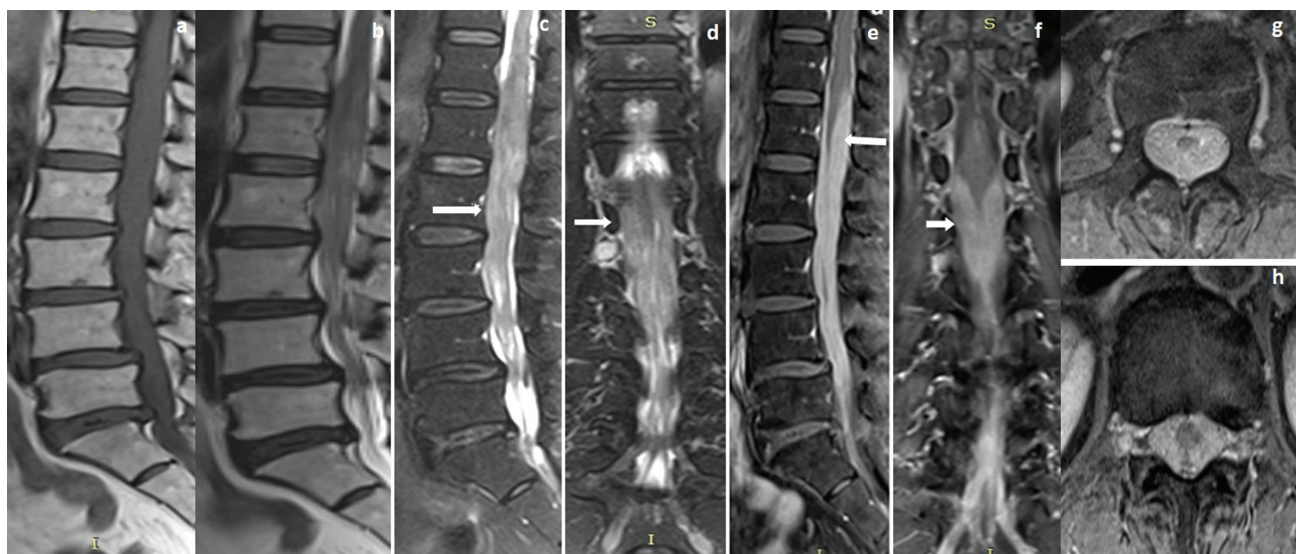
A 50-year-old female with a diffuse pattern of primary lymphoma presented with chronic low backache with saddle perianal anesthesia. Sagittal T1-weighted (T1W), T2W, and short tau inversion recovery (STIR) images (A–C) showed long segmental T1 iso, T2, and STIR iso to slight hyperintense sheet-like intradural lesions (arrow) extending from D12 to S1 vertebral level. Coronal STIR image (D) showed the sheet-like lesions along the cauda equina nerve fibers. Sagittal, coronal, and axial postgadolinium T1W images (E–H) showed homogenous sheet-like enhancement around the conus medullaris and along the cauda equina fibers.
